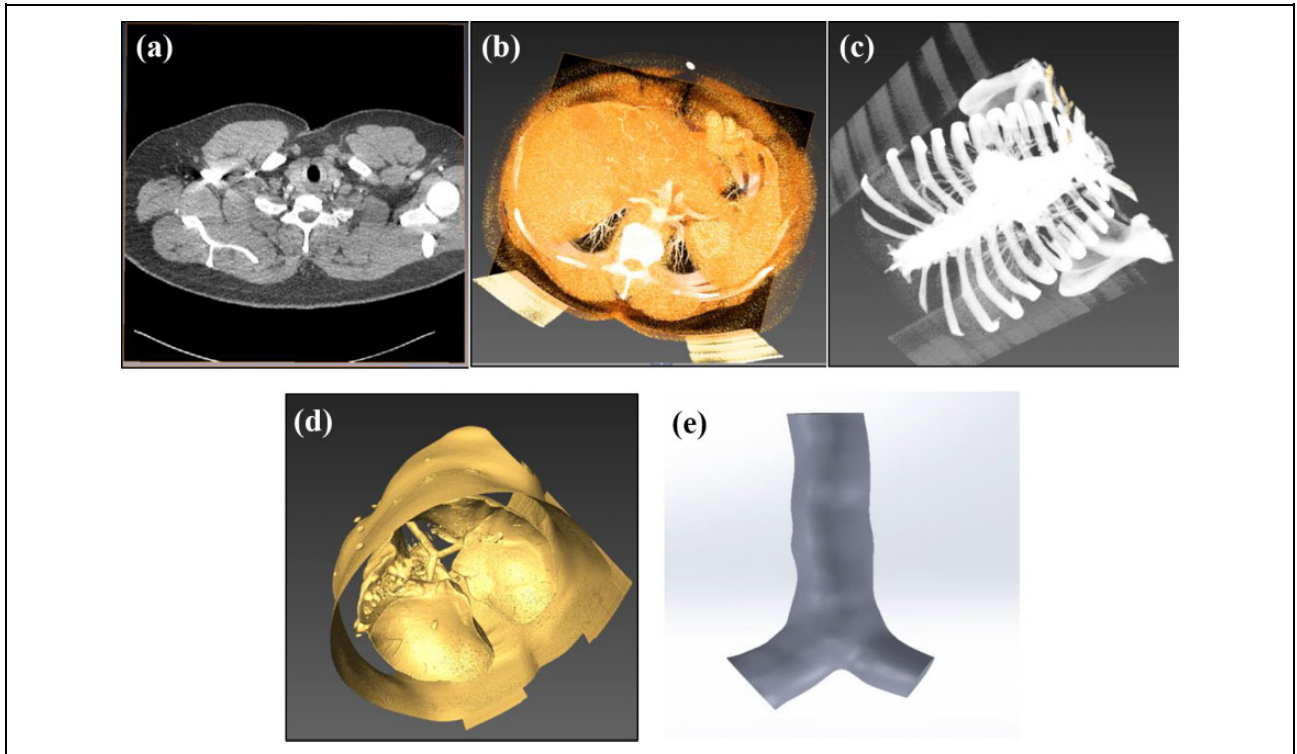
(a) Raw CT image and cross-sectional view, (b) cross-sectional view with volren, (c) image of lung airway with the skeleton, (d) image of lung lobes, and (e) 3-D anatomy of the lung for the central airway. CT: computed tomography.
